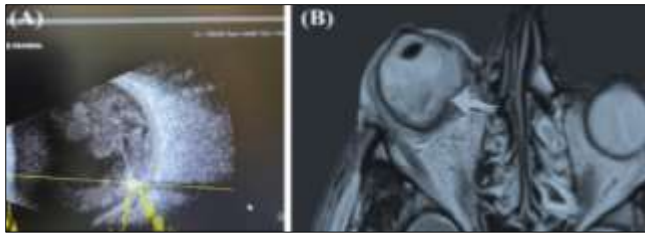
(A) showing B- scan ultrasonography of dome shaped choroidal mass; the lesion presents acoustic hollowness at its base. (B) The lesion is hyperintense on T1 weighted images. (C) hypointense on T2 weighted images.
